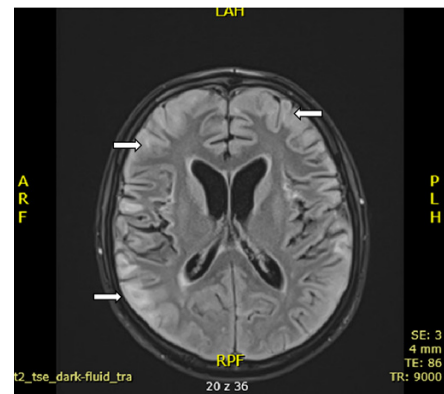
MRI scan during the patient's stay in the Paediatric Neurology Department. White arrows indicate a new area of high signal intensity in the parenchyma
